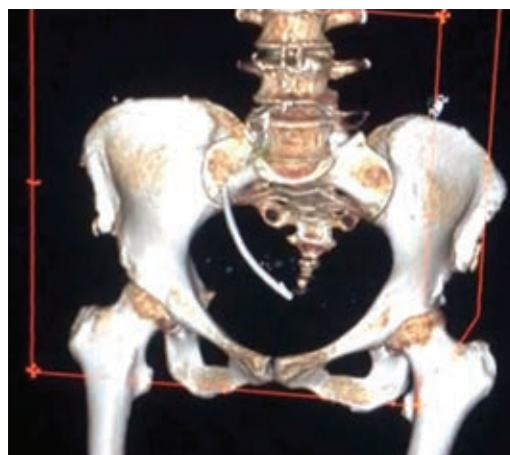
Three-dimensional reconstruction of a CT scan showing a high-density tubular opacity to the left of the midline, consistent with a biliary stent at the level of the sigmoid colon.
